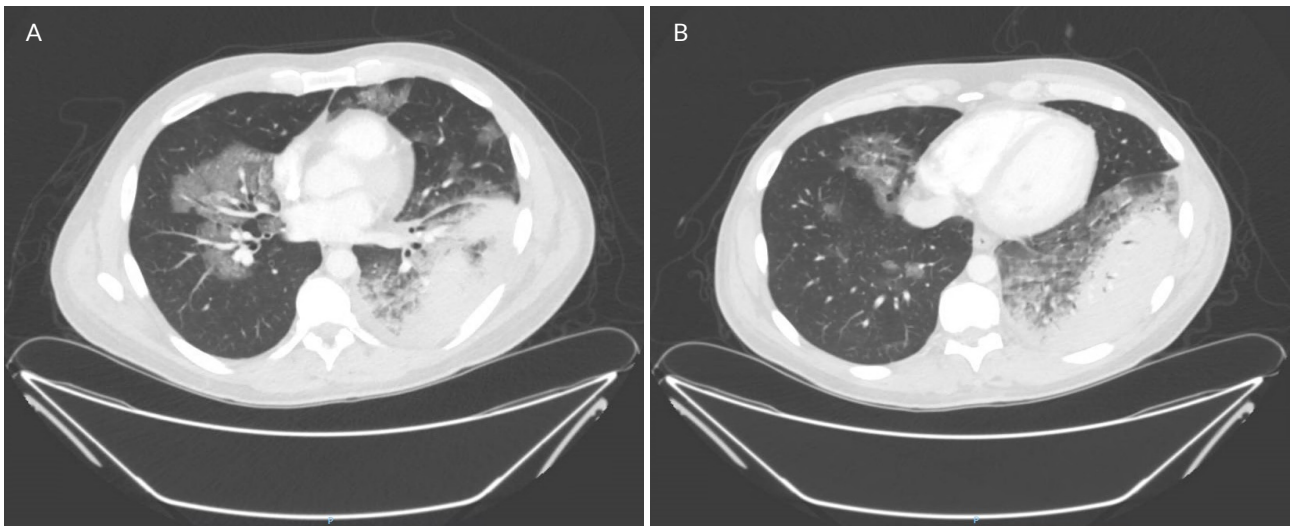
A CT scan of the thorax showing extensive dense consolidation of the left lower lobe with small left-sided effusion.
